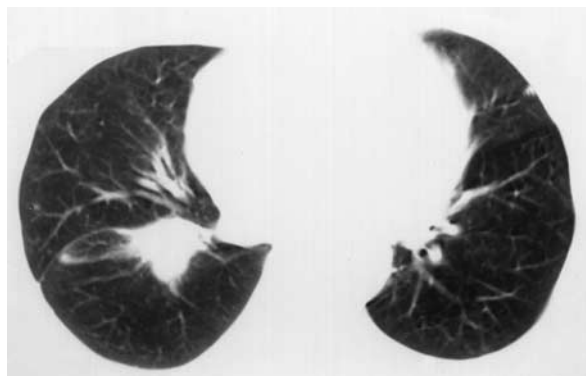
CT Scan of the Thorax.
